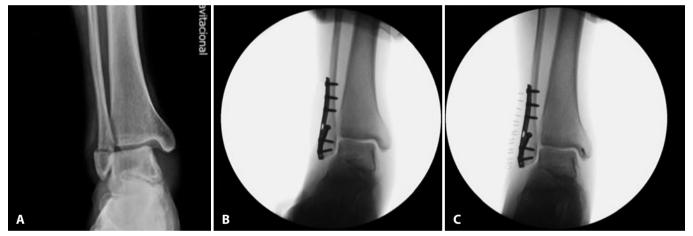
A) Manual stress X-ray, lateral malleolus fracture 44B3.1, medial clear space widening \geq 5 mm. B) Residual medial instability. C) Repair with an anchor. Source: Authors' personal archive.
